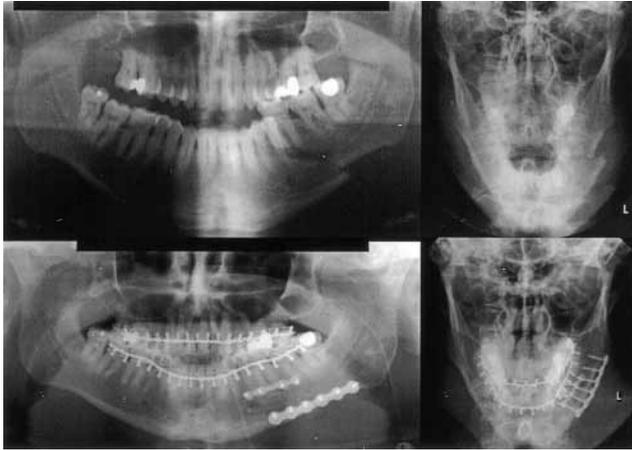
Pre- and postoperative x-rays of a severe dislocated fracture, mandibular body left. Fixation with two Mini-Locking-Plates (small and medium).
